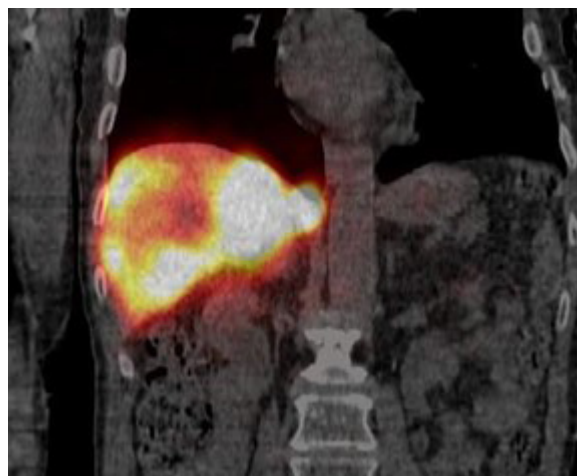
Tc-99m MAA SPECT-CT image used to predict the distribution of Y-90 SIRT.
